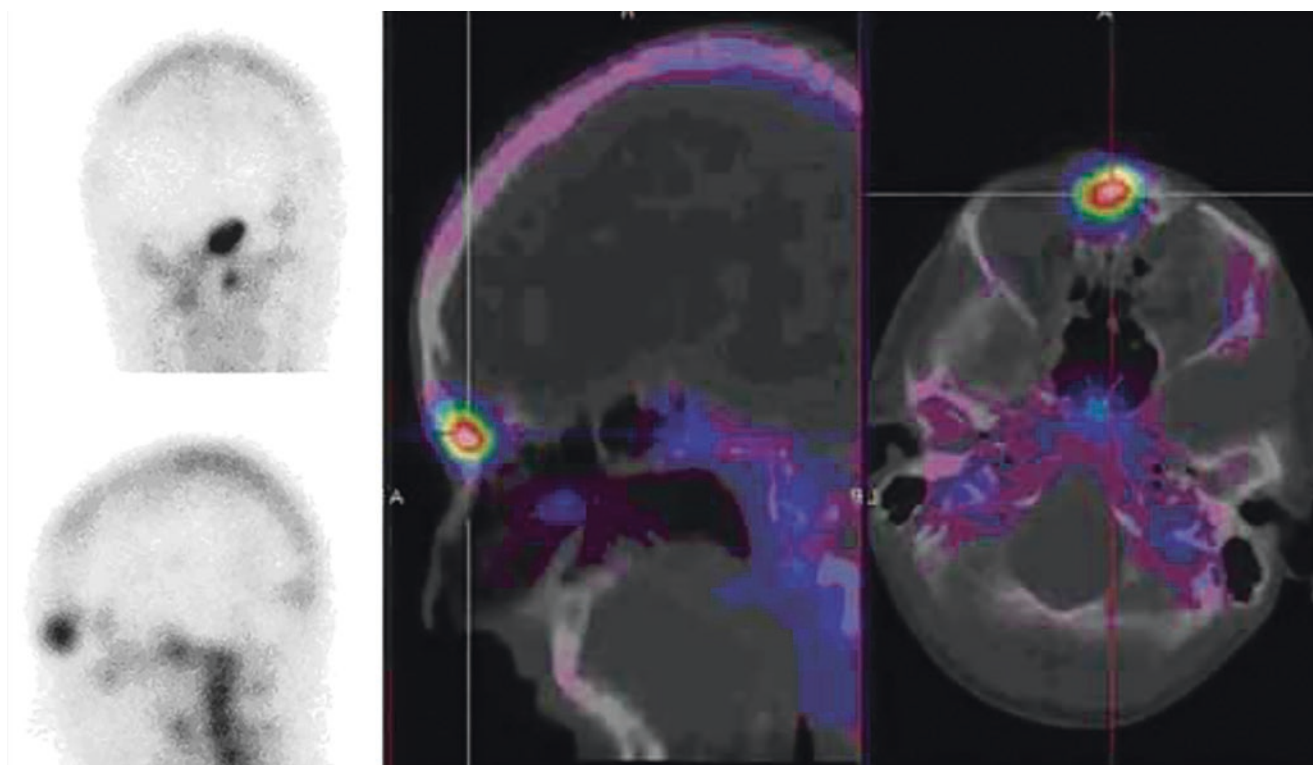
^{99m}Tc -HMPAO-WBC scintigraphy performed in a patient with suspected frontal osteomyelitis. Left panel: planar anterior (upper) and left lateral (lower) images acquired 4 h post-injection, showing focal accumulation of labeled leukocytes in the frontal region. Right panel: fused SPECT/CT images (sagittal, left; axial, right), showing
